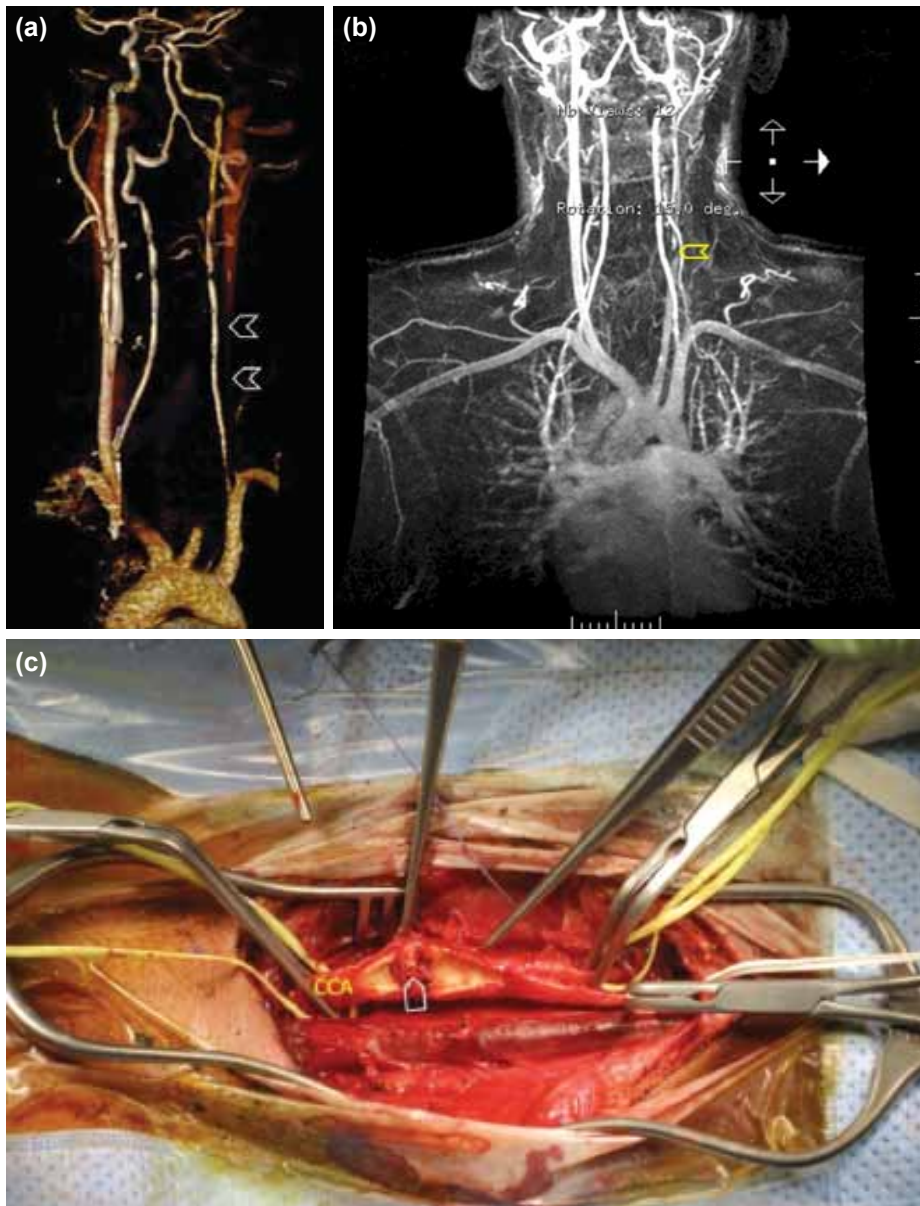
(a) CT angiography showing that the left CCA was non-contrasted from its origin up to the carotid bifurcation (arrow heads) and a good back flow in the circle of Willis. (b) MR angiogram with contrast showing intimal tear in the left CCA 2-3 cm below the bifurcation (arrow head). (c) Arteriotomy showing dissection of the distal part of the left CCA, about 2 cm below the bifurcation.
